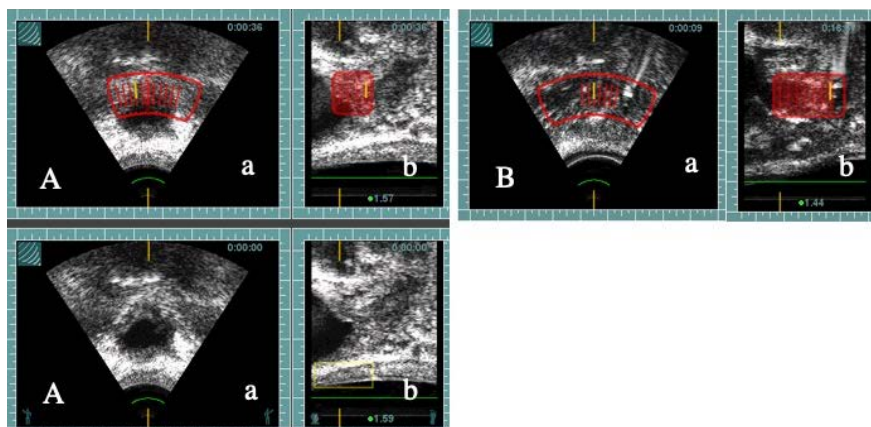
Ultrasound images during HIFU. (A) Sonication field in upper half of the urethra in case 2. (B) Marking the distal portion of the external sphincter with a biopsy forceps. (a) Sector section view (b) Linear section view.
